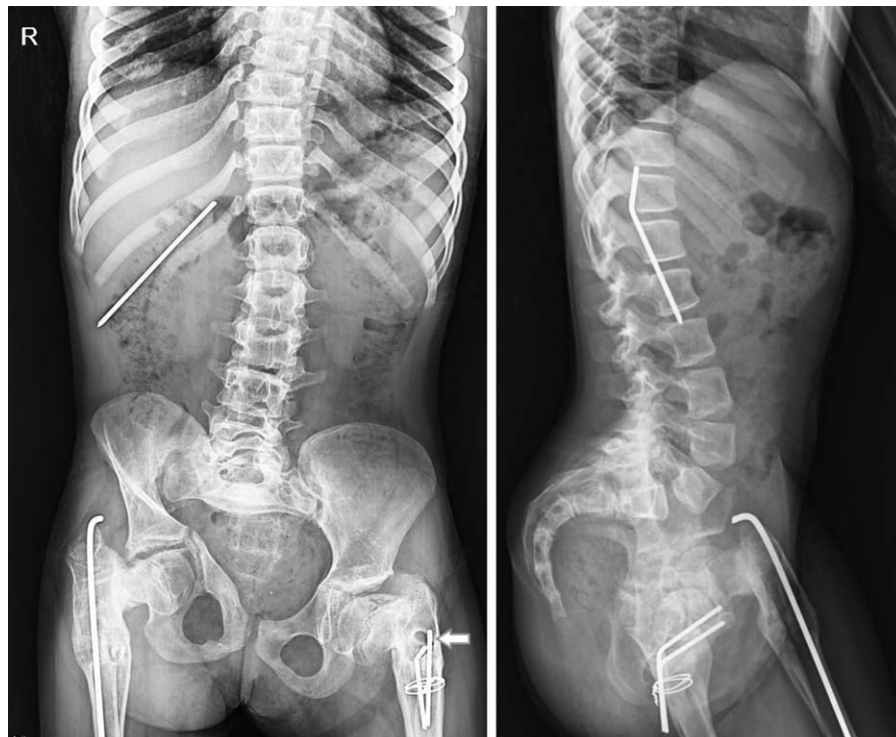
Anteroposterior and lateral x-rays clearly depicting a K-wire in the right hypochondrial region. A lucent area (arrow) suggests loosening of the wire before migration.
